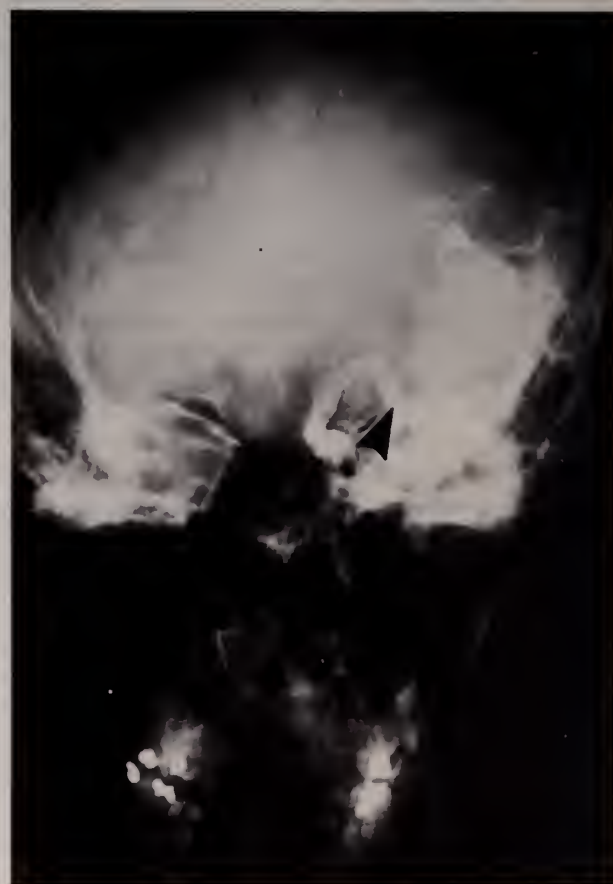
The ultrasonic arteriogram demonstrates the AVM filling from the terminal MCA (arrow).
